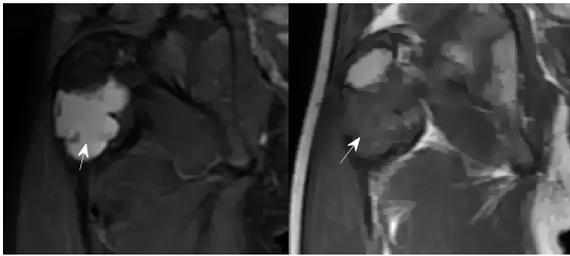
A bone cyst visualised on a single slice coming from two different MR coronal series: left – STIR, right – FSE T1-weighted.
